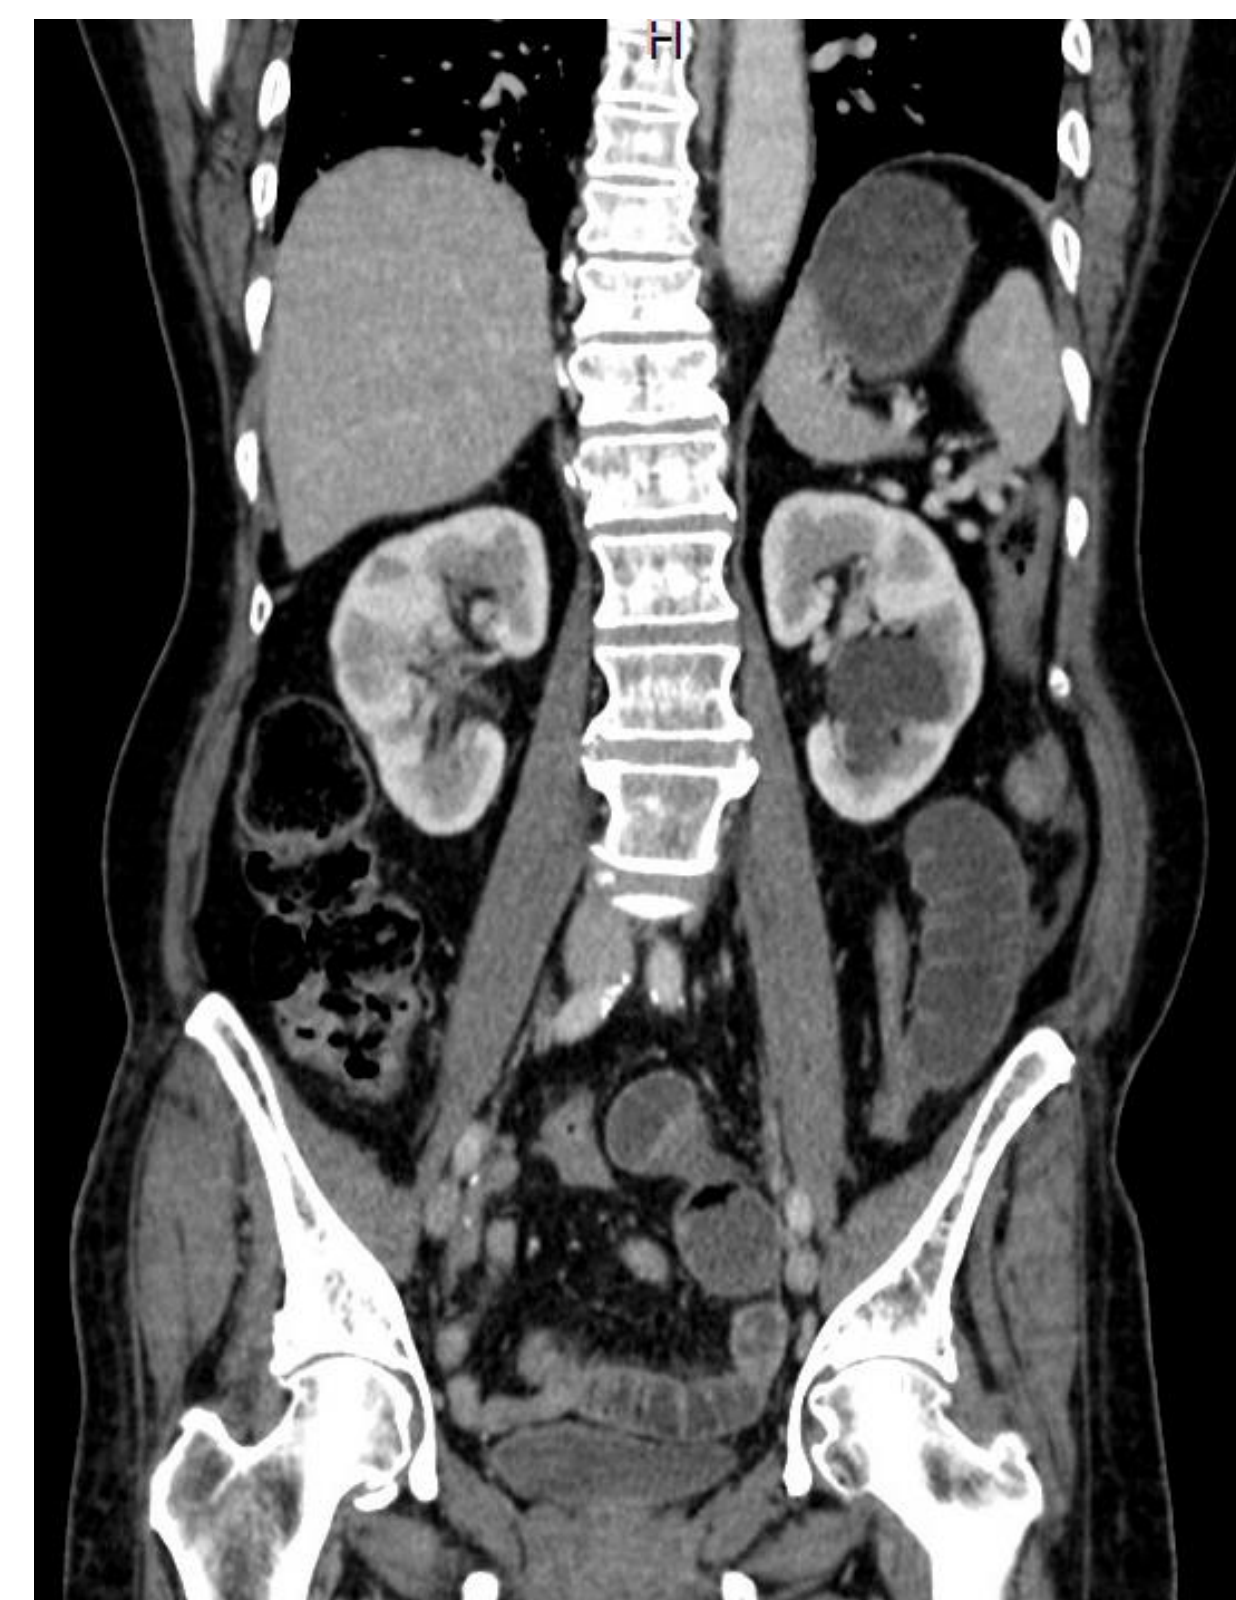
Coronal CT LLQ transition point
